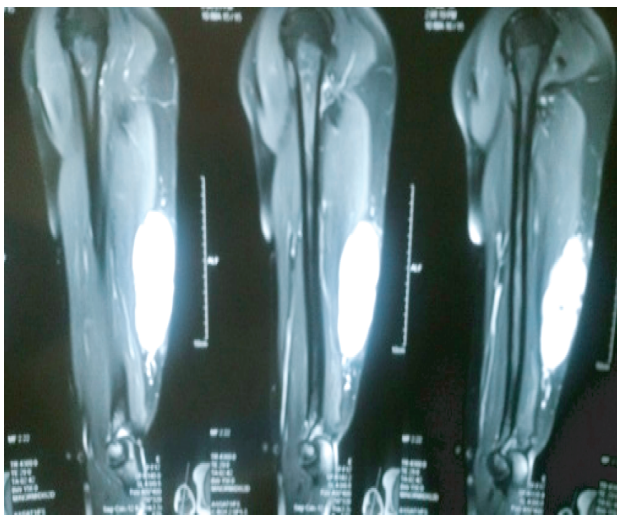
MRI reveals large lobulated soft tissue intensity mass comprising the lateral and long head of triceps.
